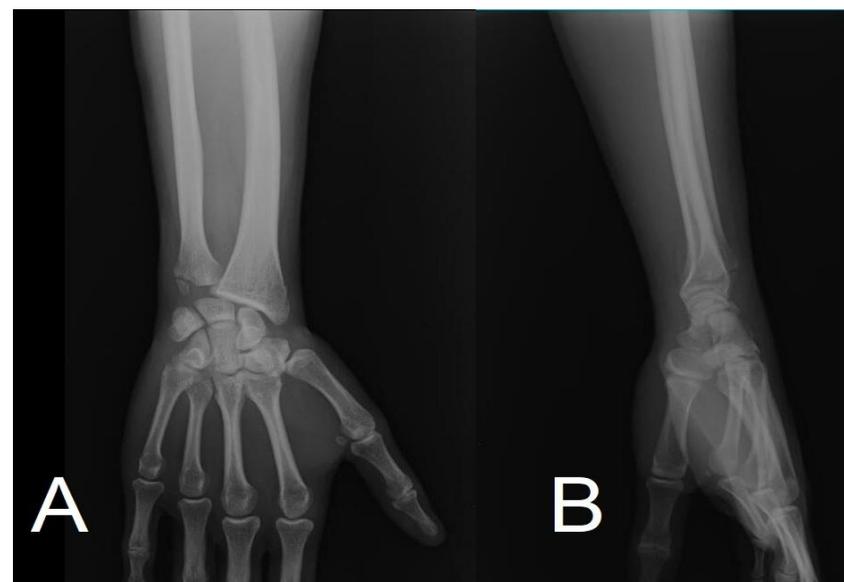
7-months follow-up posteroanterior (A) and lateral (B) radiographs
